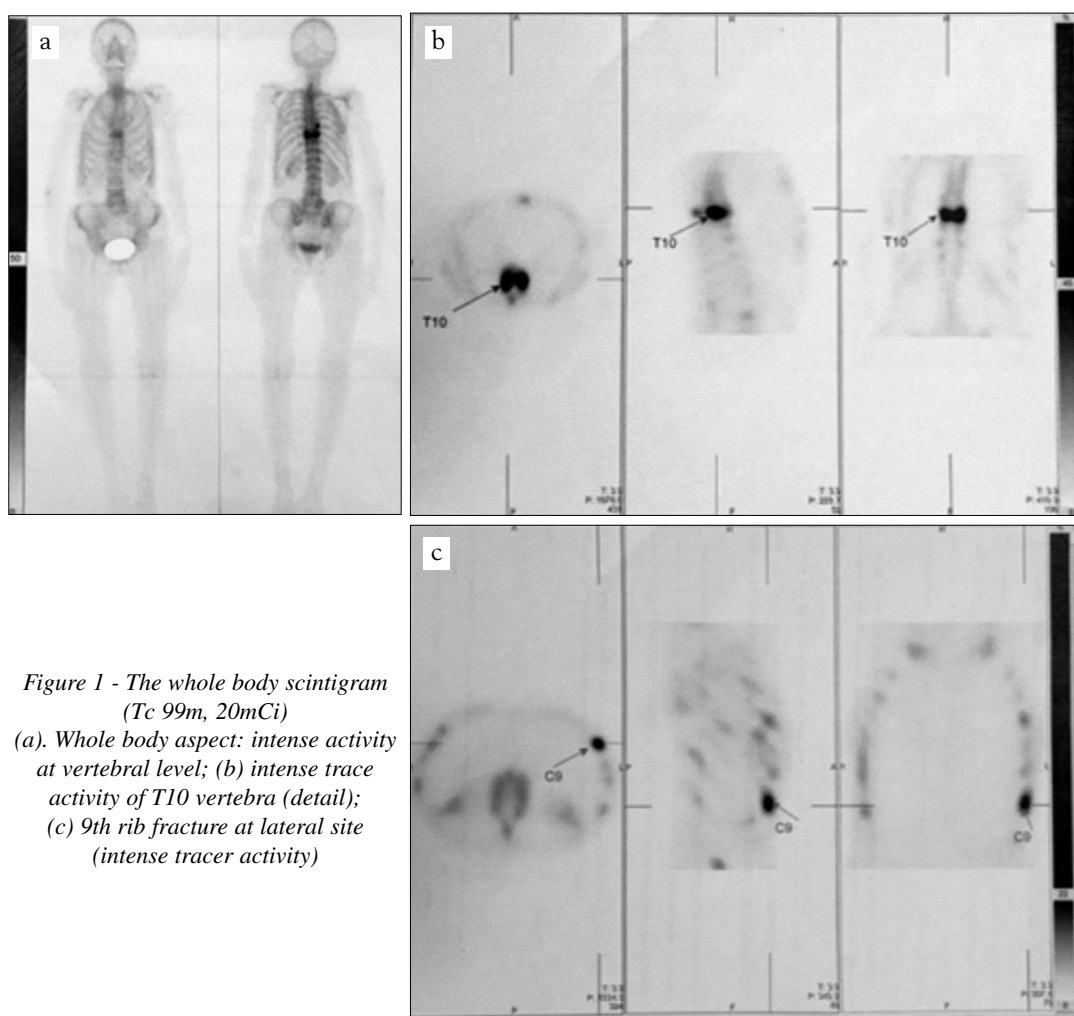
The whole body scintigram (Tc 99m, 20mCi)
